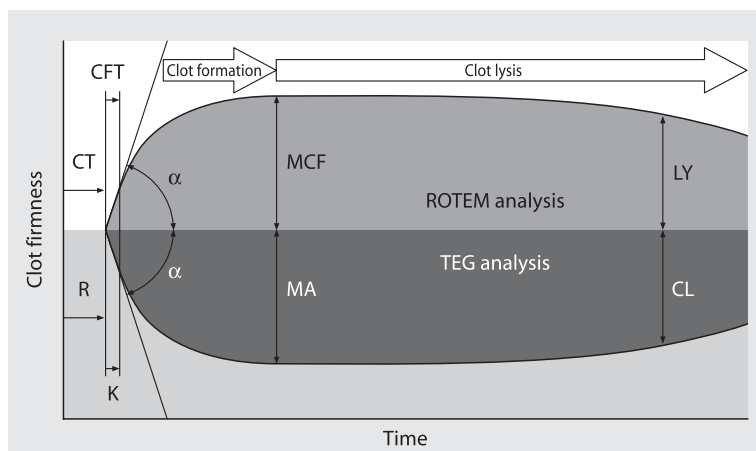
Typical TEG/ROTEM® tracing. R: reaction time; K: kinetics; α : slope between R and K; MA: maximum amplitude; CL: clot lysis; CT: clotting time; CFT: clot formation time; α : slope of tangent at 2 mm amplitude; MCF: maximal clot firmness; LY: Lysis. For detailed description and reference values please see Tables 2 and 3.
